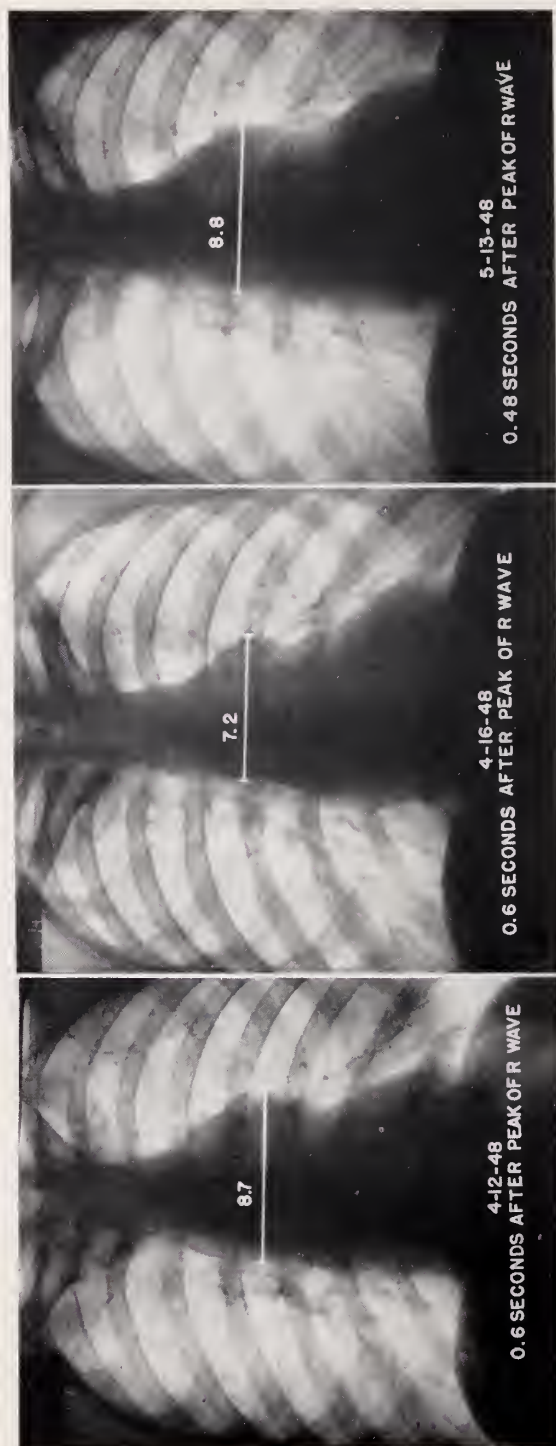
As Figure 1, but roentgenograms made during diastole
